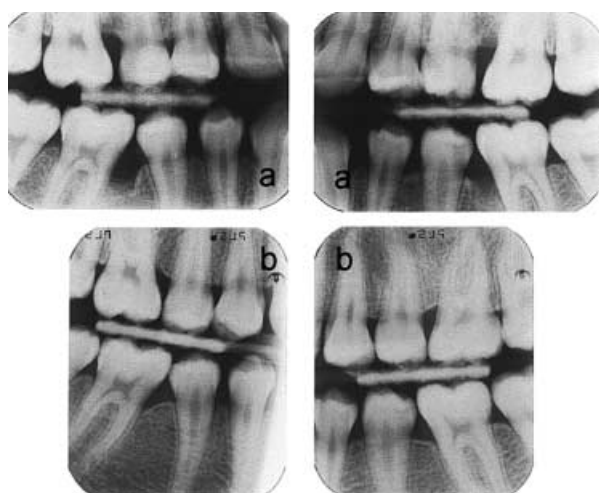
Bitewing radiographs of the oldest son before treatment was initiated (a) and one year after treatment (b). Healing of the marginal crest at the first molars is evident.
